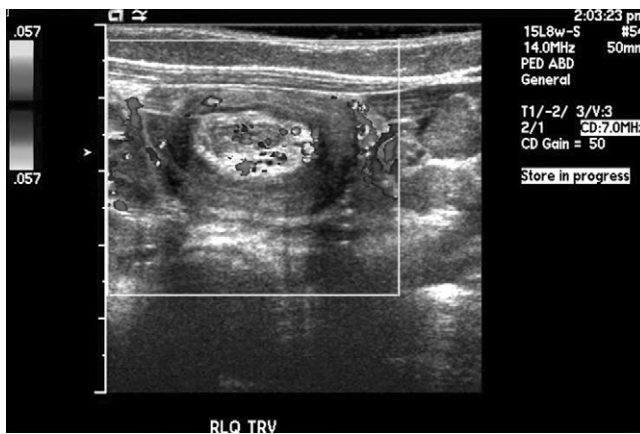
Duplex ultrasonography showing the target sign of an intussusception and confirming viability of the intussusceptum.
